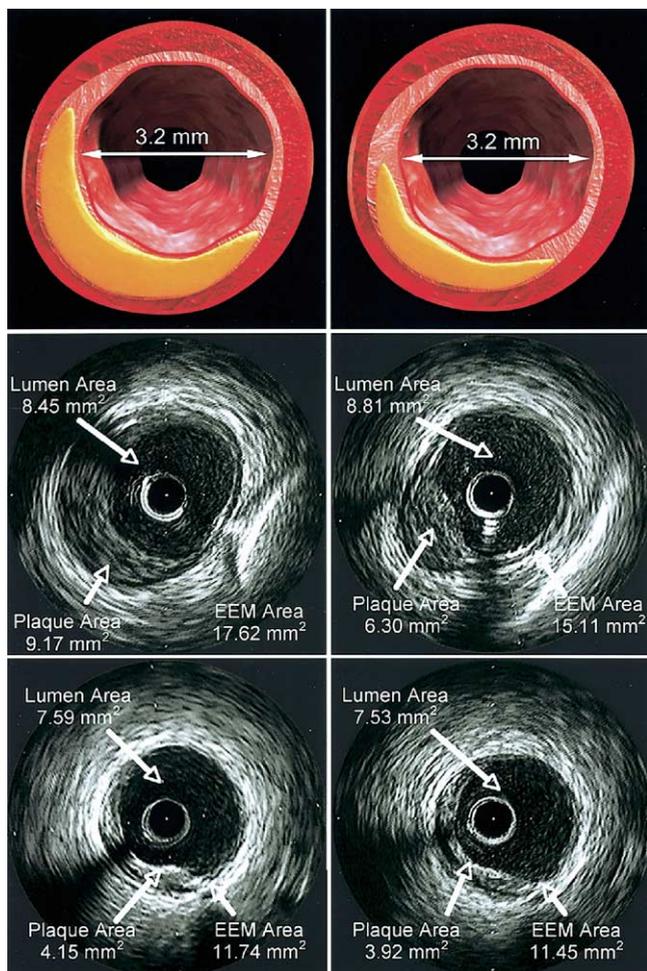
Representative cross-sectional intravascular ultrasound images of matched arterial segments at baseline (left) and follow-up (right). At sites that underwent atheroma regression in response to infusions of reconstituted high-density lipoprotein cholesterol containing recombinant human apolipoprotein A-I Milano (top and middle panels), there was concomitant reduction in external elastic membrane (EEM) area with no change in the lumen size. At sites where there was no change in plaque area (bottom panels), there was no change in either the EEM or lumen.
